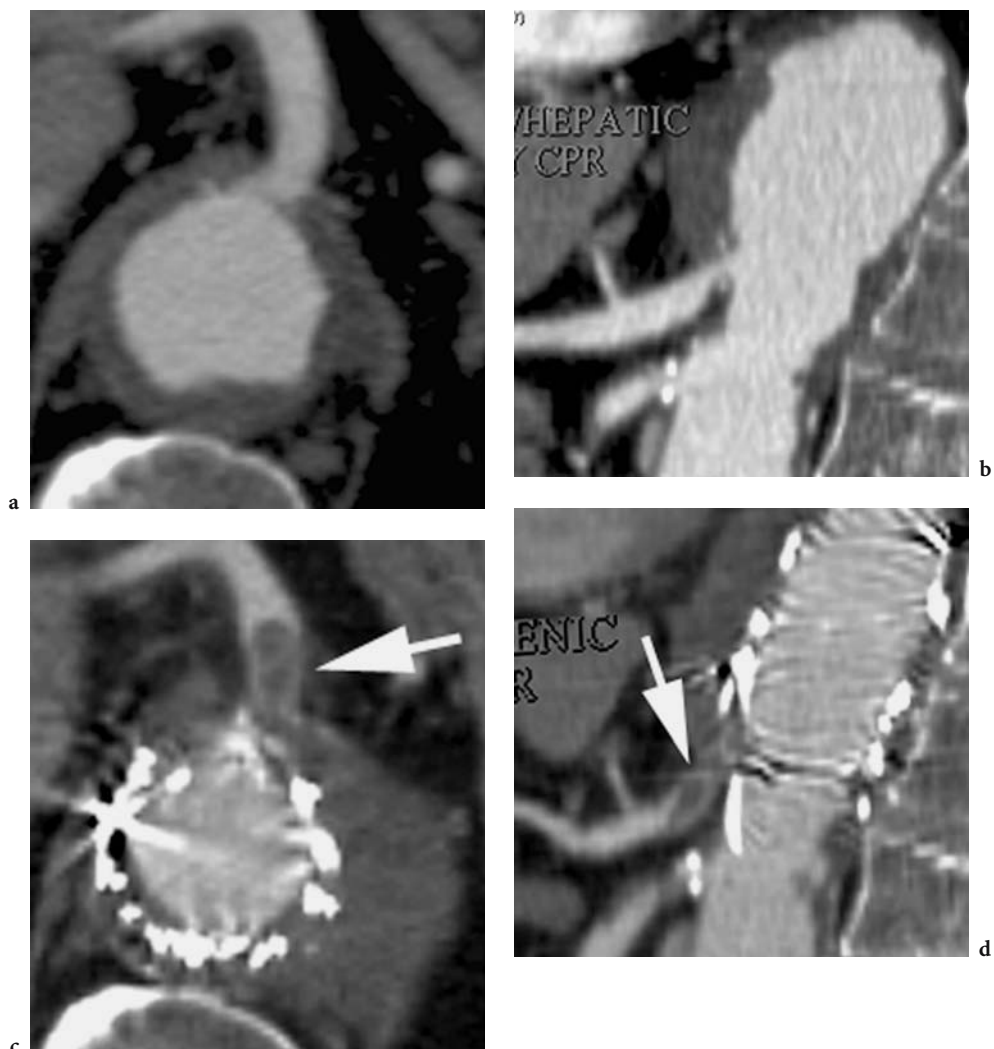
a Transverse sections and b curved sagittal reformation through the celiac origin demonstrates a celiac origin stenosis at the distal extent of a thoracoabdominal aortic aneurysm. c Transverse CT section and d curved sagittal reformation following treatment of the thoracoabdominal aortic aneurysm with a stent graft demonstrates inadvertent occlusion of the celiac origin with thrombus (*arrows*) present in the proximal centimeter of the celiac axis
